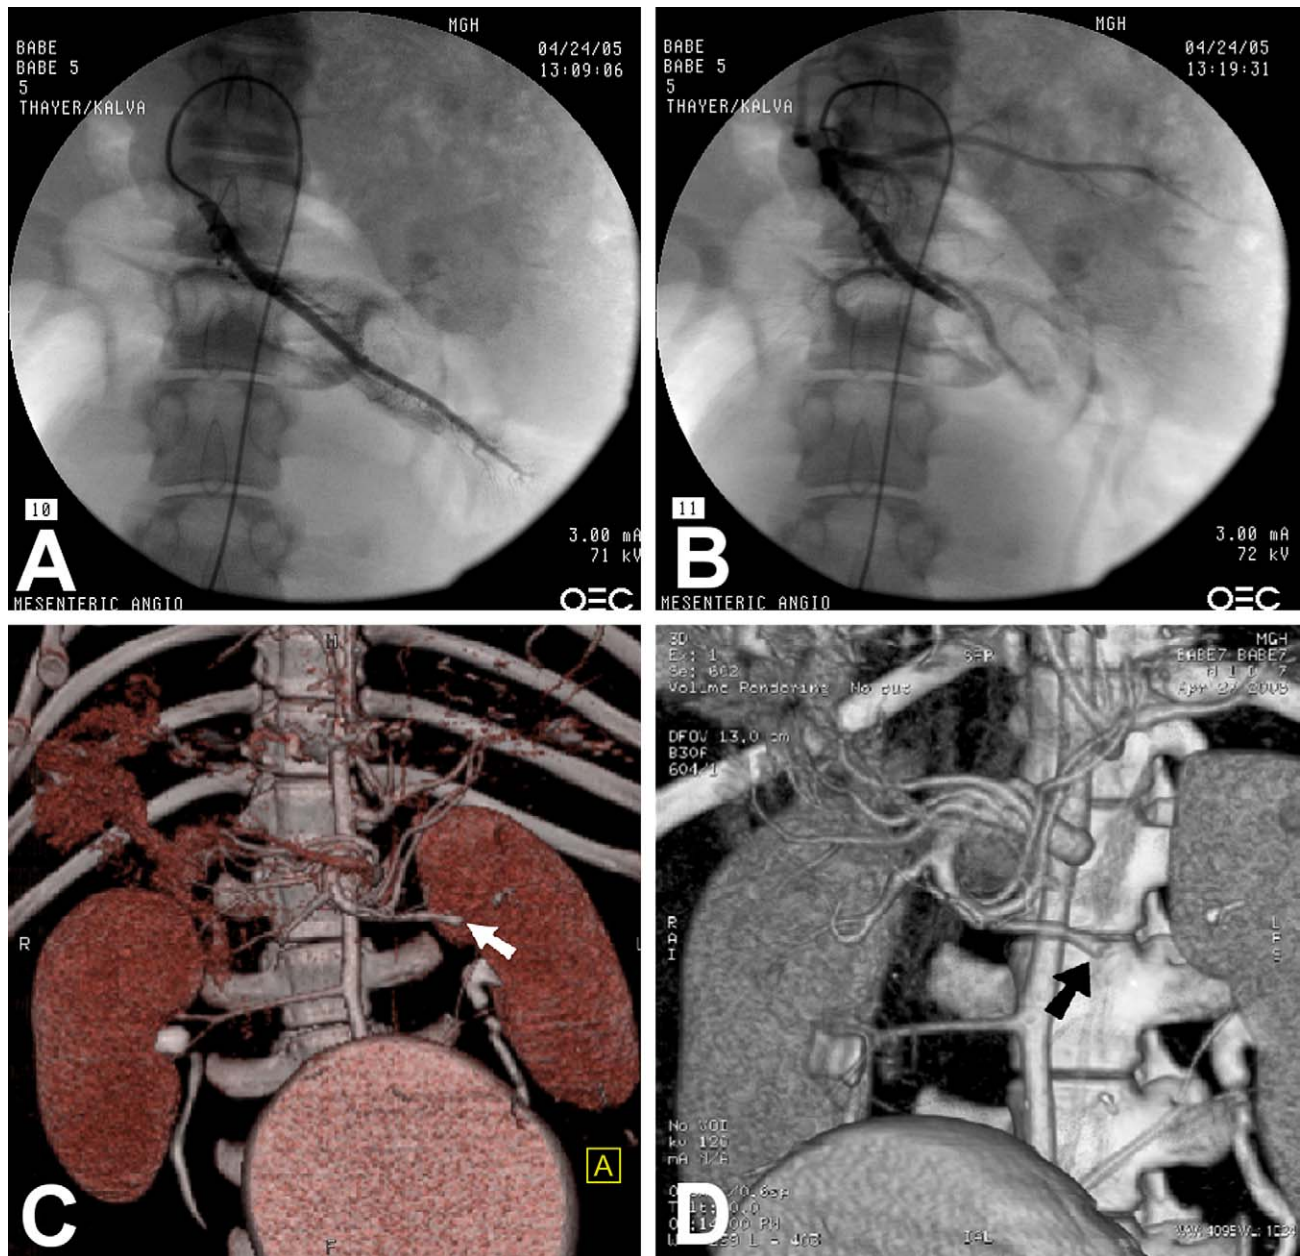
Accurate identification and detection of occluded arterial anatomy by M.D.CT-CTA. (A) Fluoroscopic angiography demonstrates normal filling pattern of jejunal branch of superior mesenteric artery. (B) Angiography postembolization reveals occluded jejunal branch. (C) M.D.CT-CTA using volume rendered technique demonstrates the occlusion of the jejunal branch of the SMA (*white arrow*). (D) M.D.CT-CTA using MIP three-dimensional reconstruction demonstrates the occlusion of the jejunal branch of SMA (*black arrow*).
